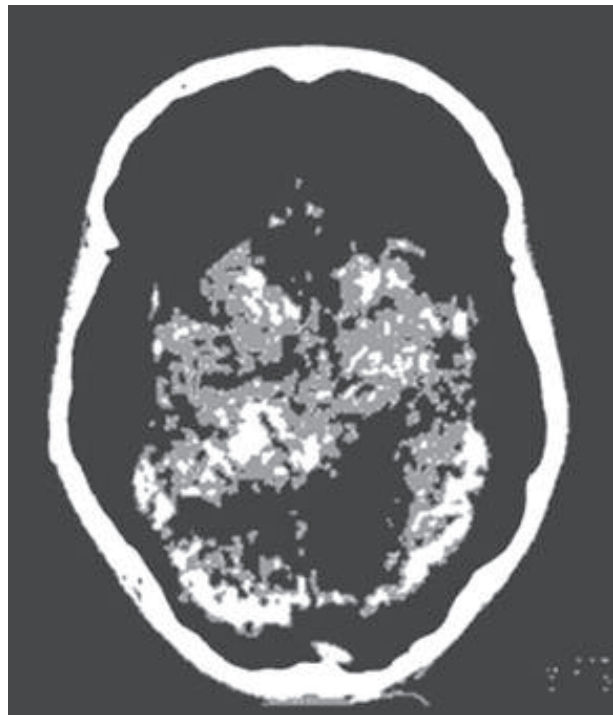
CT of the Iceman’s brain with typical shrinking signs
